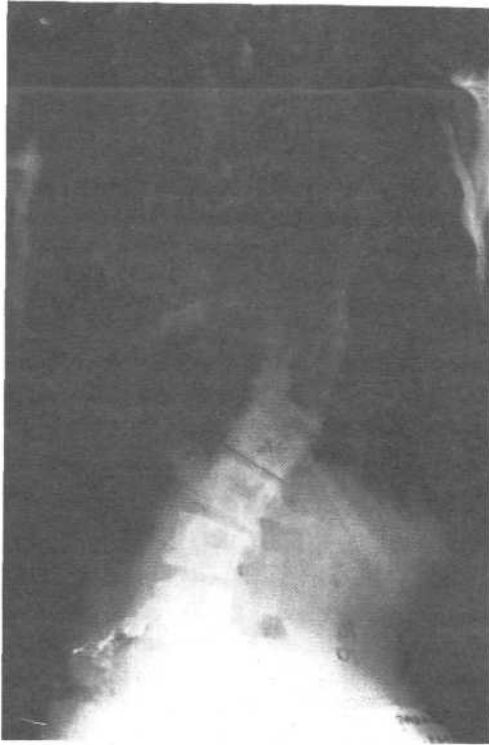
Pre-operative roentgenograms of a 14 year old girl with 56° lying and 39° bending Cobb angle.
